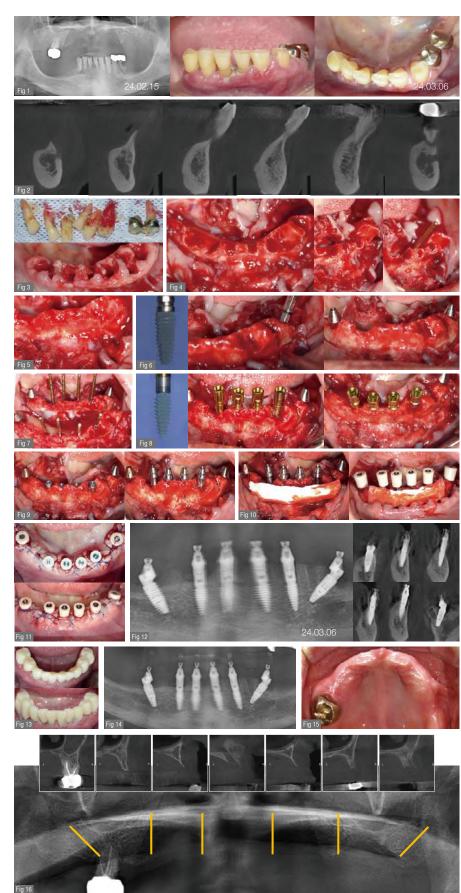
Postoperative panoramic and CBCT radiographs
